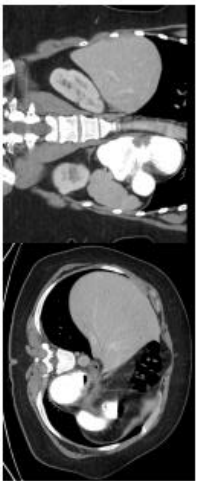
The operative abdominal CT scan, showing a presumed type IV paraesophageal hernia.
